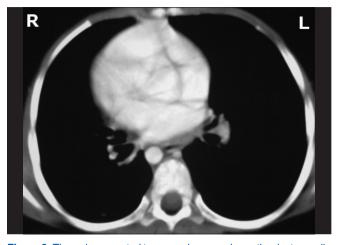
Thoracic computed tomography scan shows the dextrocardia
